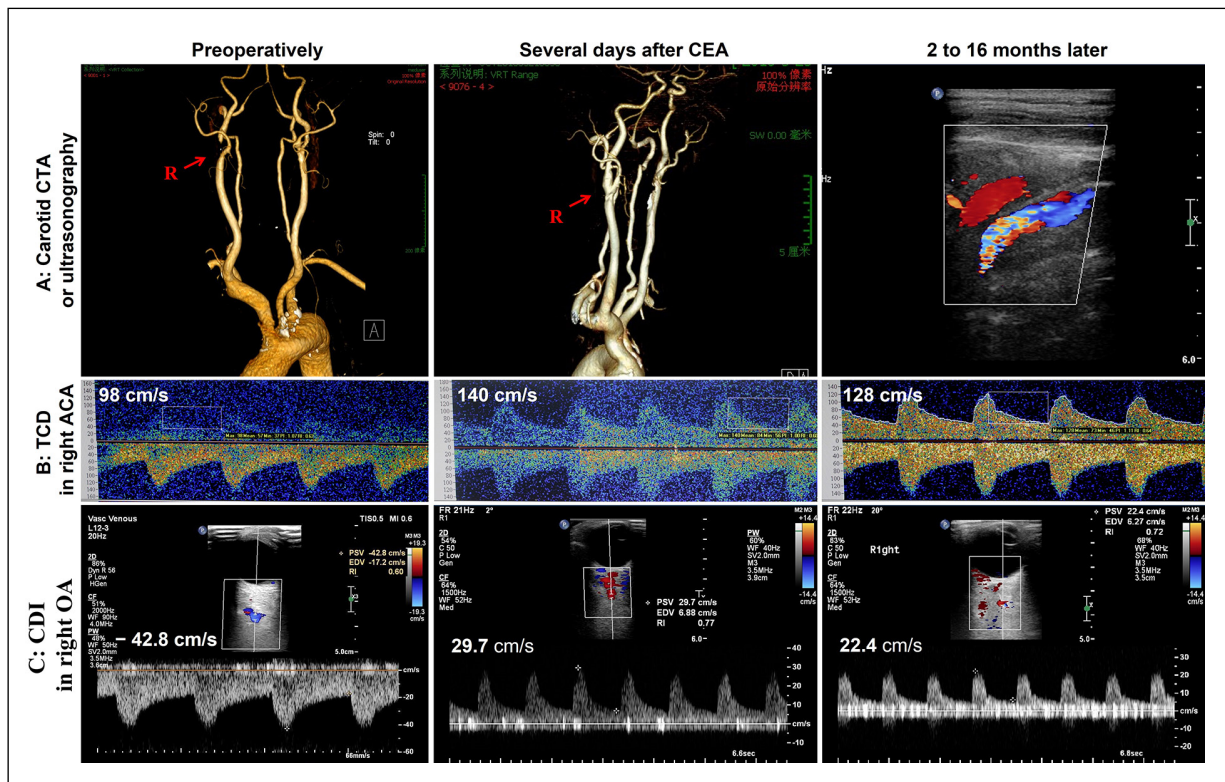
Image data acquired from a 68-year-old woman with right 95% carotid stenosis. A, Right-sided CEA was successfully performed to resolve carotid stenosis, and good patency of carotid artery was confirmed by postoperative CTA and two-month follow-up color Duplex ultrasound scanning. B, The BFVs in right ACA increased from 98.0 cm/s to 140.0 cm/s at three days postoperatively, and eventually decreased to 128.0 cm/s at the follow-up of two months following CEA. C, Preoperative reversed OA flow resolved after undergoing CEA. The postoperative BFVs of the ipsilateral OA were 29.7 cm/s and 22.4 cm/s at three days postoperatively and two months later, respectively. CEA, Carotid endarterectomy; CTA, computed tomography angiography; BFV, blood flow velocity; ACA, anterior cerebral artery; OA, ophthalmic artery.
